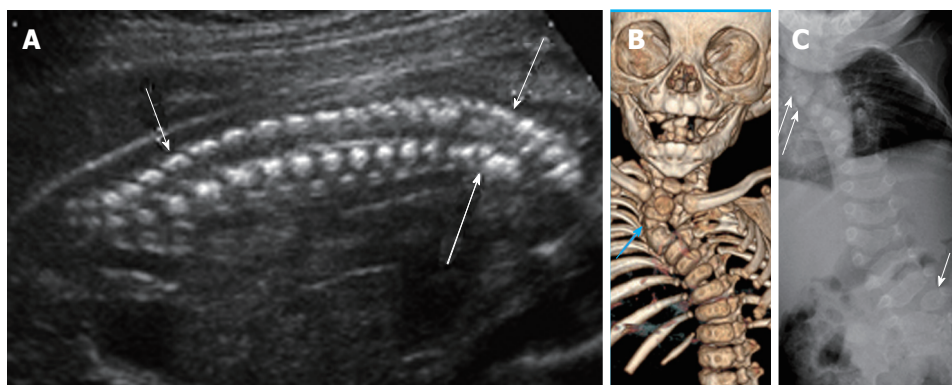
Cervicothoracic Hemivertebrae. Grayscale ultrasound image (A) of a 21 wk fetus demonstrate multiple hemivertebrae (arrows) and cervicothoracic kyphosis. Six months postnatal multidetector unenhanced computed tomography of the thorax with volume rendering (B) as well as frontal radiograph of the spine (C) demonstrate multiple vertebral segmentation anomalies, including right upper thoracic and left lumbosacral hemivertebrae (arrows), resulting in congenital cervicothoracic dextroscoliosis.
